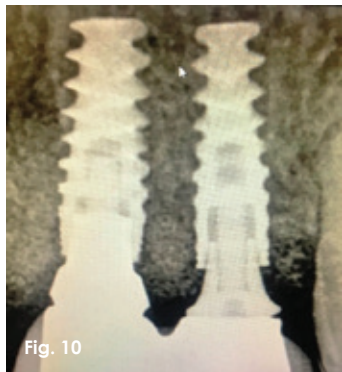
Radiographic images of implant placed
